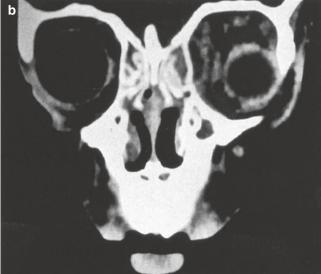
Drainage of ethmoid sinuses and medial orbit. (a) A 10-year-old patient with orbital cellulitis, ethmoid sinusitis, and a medial subperiosteal abscess. (b) Coronal CT scan demonstrating the radiologic findings; note the medial periosteal elevation over the ethmoid sinuses. (c) The abscess is drained through a Lynch incision and an endonasal approach
